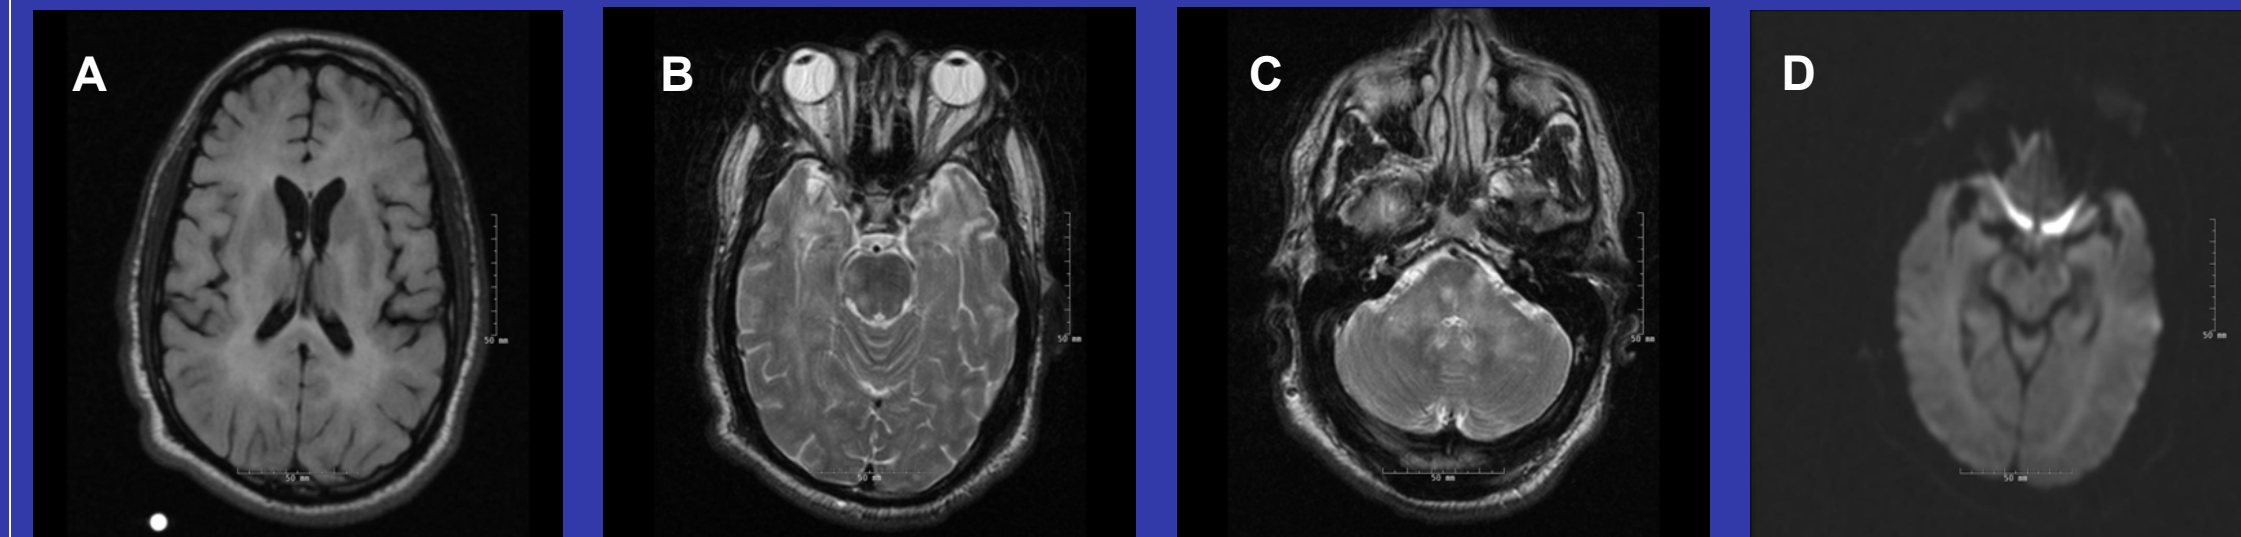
Baseline MRI Brain before initiation of natalizumab. Extensive T2/FLAIR lesion burden throughout the bilateral cerebral hemispheres and posterior fossa, characteristic of MS (A-C). No evidence of restricted diffusion on DWI sequences (D).
